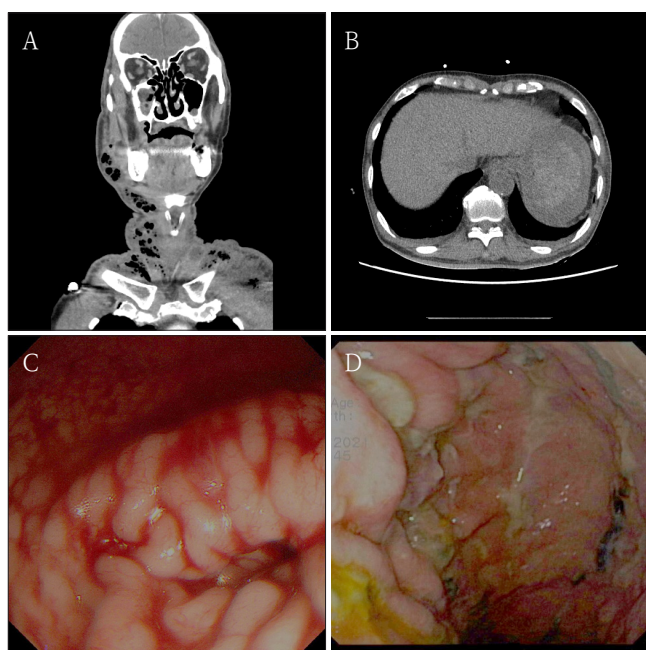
A. Computed tomography shows an abscess formation on right submandibular area extending to the deep neck. B. Computed tomography shows possible signs of hematoma in stomach. C. Endoscopy shows signs of active bleeding on upper gastric area. D. Follow-up endoscopy shows improvement of ulceration.
